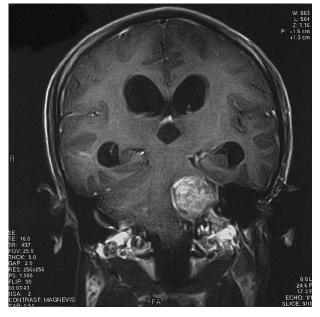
T1 weighted MRI showing dumbbell-shaped mass.
